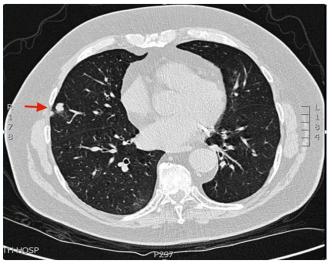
CT Thorax demonstrating a 15mm lobulated nodule in the right middle lobe.
